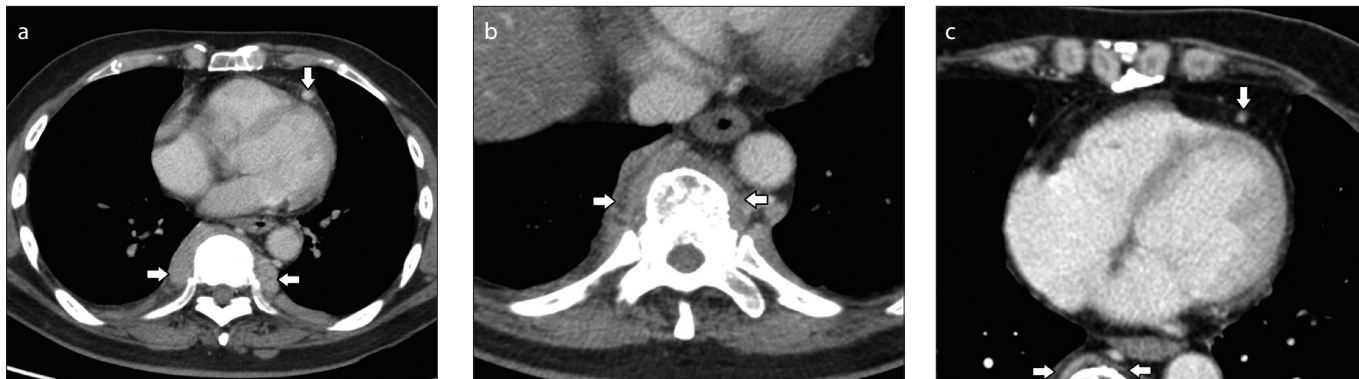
a–c. Axial CT image (a) through the mediastinum shows inflammatory fat stranding along the left anterior descending artery (*down arrow*) soft tissue thickening along the thoracic vertebra at T4 vertebral level (*horizontal arrows*). Axial CT image (b) shows paravertebral soft tissue thickening along the lower thoracic vertebra at T10 vertebral level (*horizontal arrows*). Axial CT image (c) in the same patient after corticosteroid therapy shows resolution of vasculitis as well as paravertebral soft tissue thickening (*arrows*).
